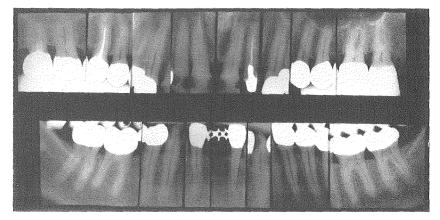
Roentgenograms of the patient in Figure 421 taken before treatment.
